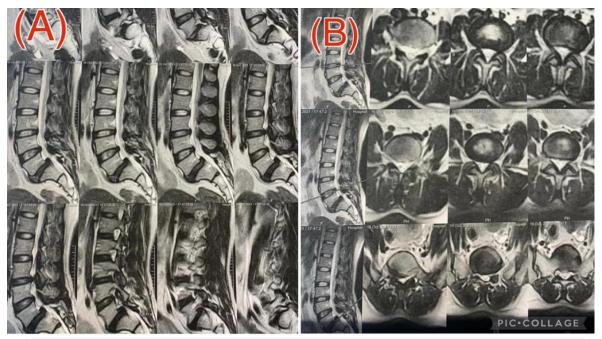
Preoperative unenhanced T2-weighted magnetic resonance image (MRI). (A) Midline sagittal image. (B)Axial section thorough L5-S1 disc space.
